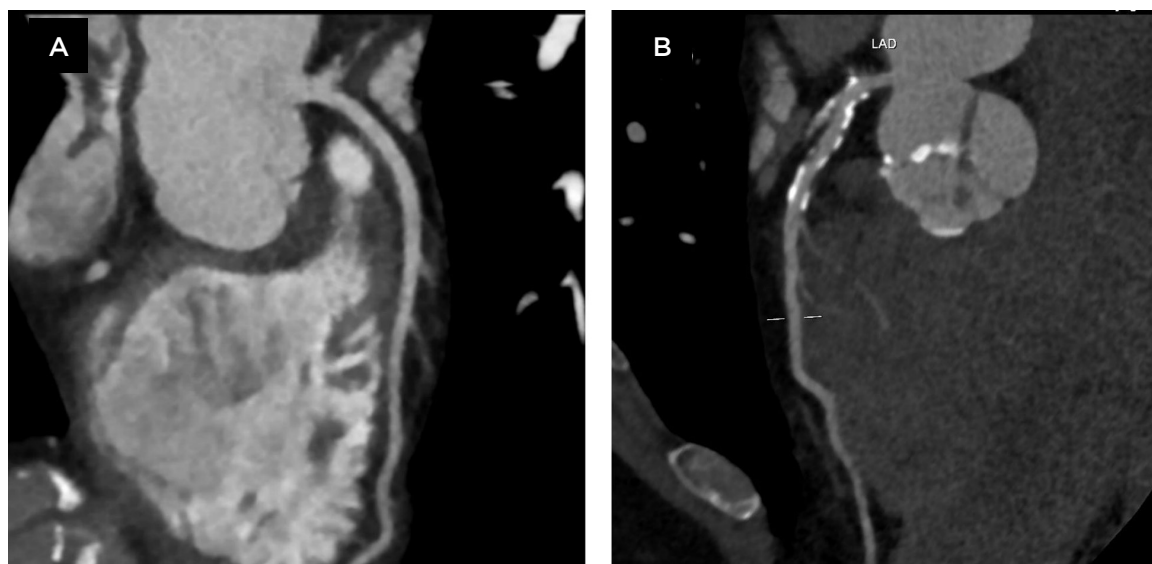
Evaluation of coronary artery disease with cardiac computed tomography angiography in diabetic patients.
